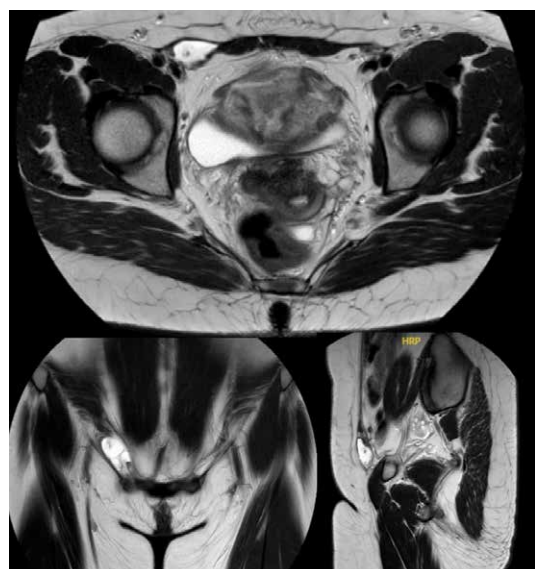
Magnetic Resonance Imaging showing a 4x2.6x1.7cm multiloculated cystic lesion not connected to the peritoneal cavity
